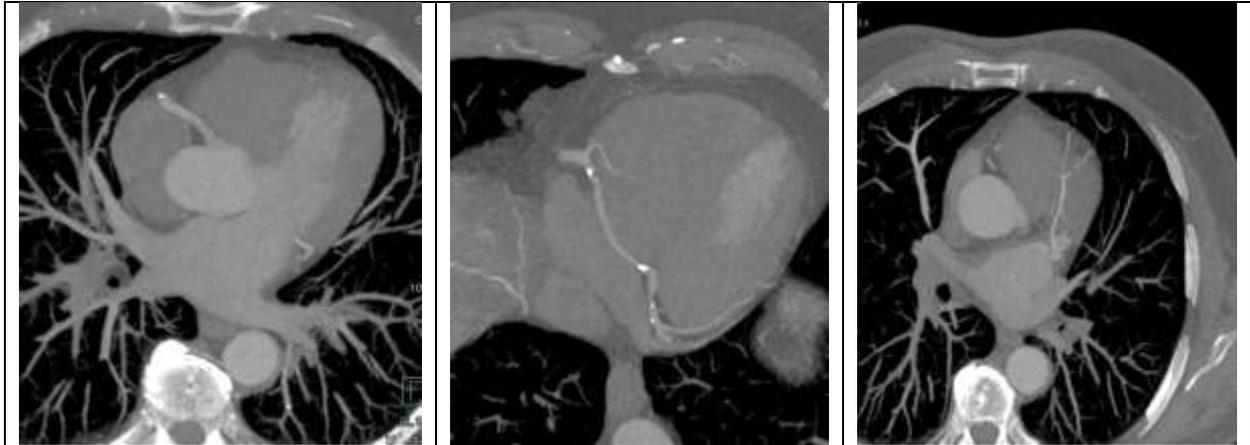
Coronary computed tomography angiography depicting an agenesis of the left main artery and its ostium with single coronary artery supplying the entire myocardium. We also note atherosclerotic coronary plaques without significant stenosis
